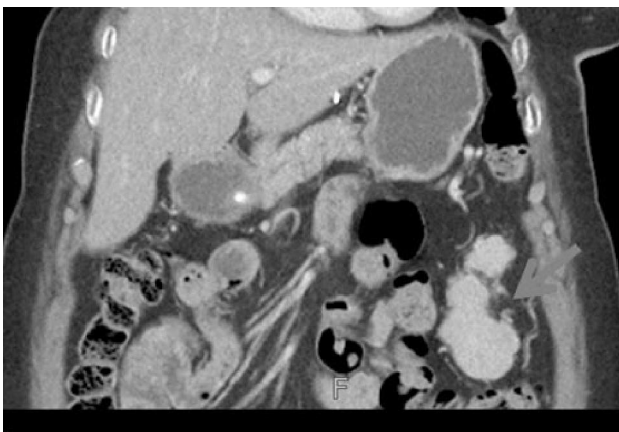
Contrast enhanced CT scan coronal section showing spleen is migrated from its usual anatomical position, to the mid lower abdomen below the anterior abdominal wall on left side with intact hilum representing wandering spleen.
